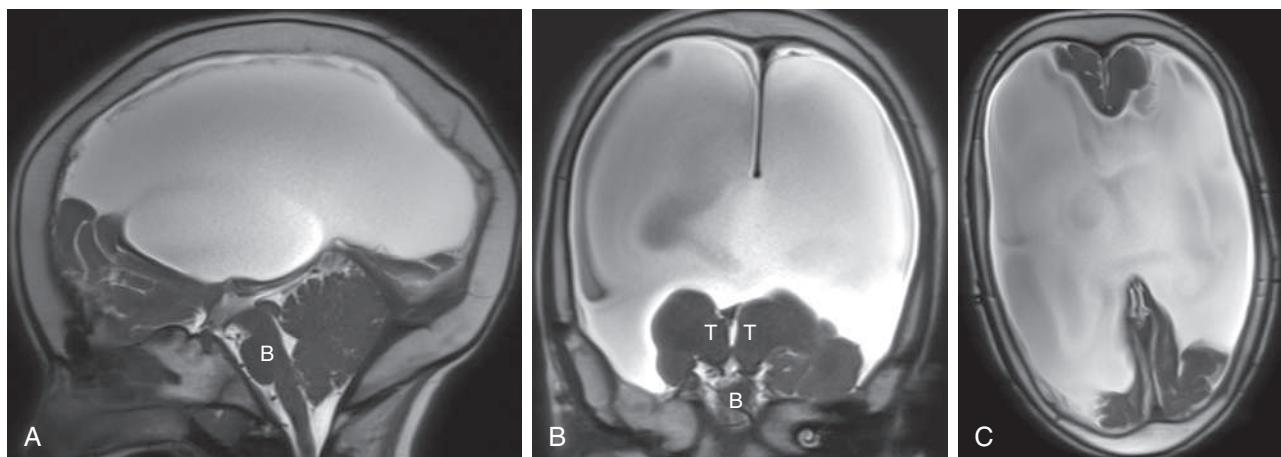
Hydranencephaly. Brain MRI sagittal (A), coronal (B), and axial (C) single-shot T2-weighted images of a 13-yr-old female with severe neurologic impairment demonstrates lysis of the cerebral hemispheres apart from small remnants of the frontal/occipital poles and left temporal pole. There is preservation of the thalamus (T) and brainstem (B). This congenital lysis of the cerebrum is dubbed hydranencephaly and believed to reflect anterior circulation vascular insufficiency in utero.
